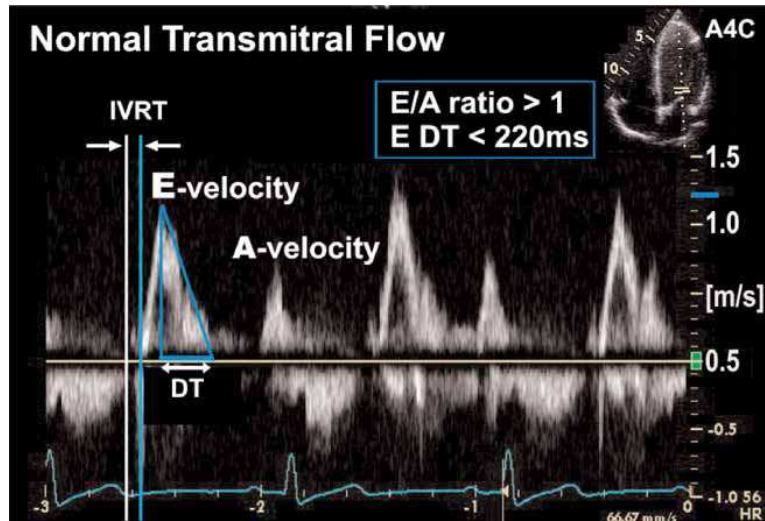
Normal transmittal Doppler flow (DT = deceleration time) (37).
